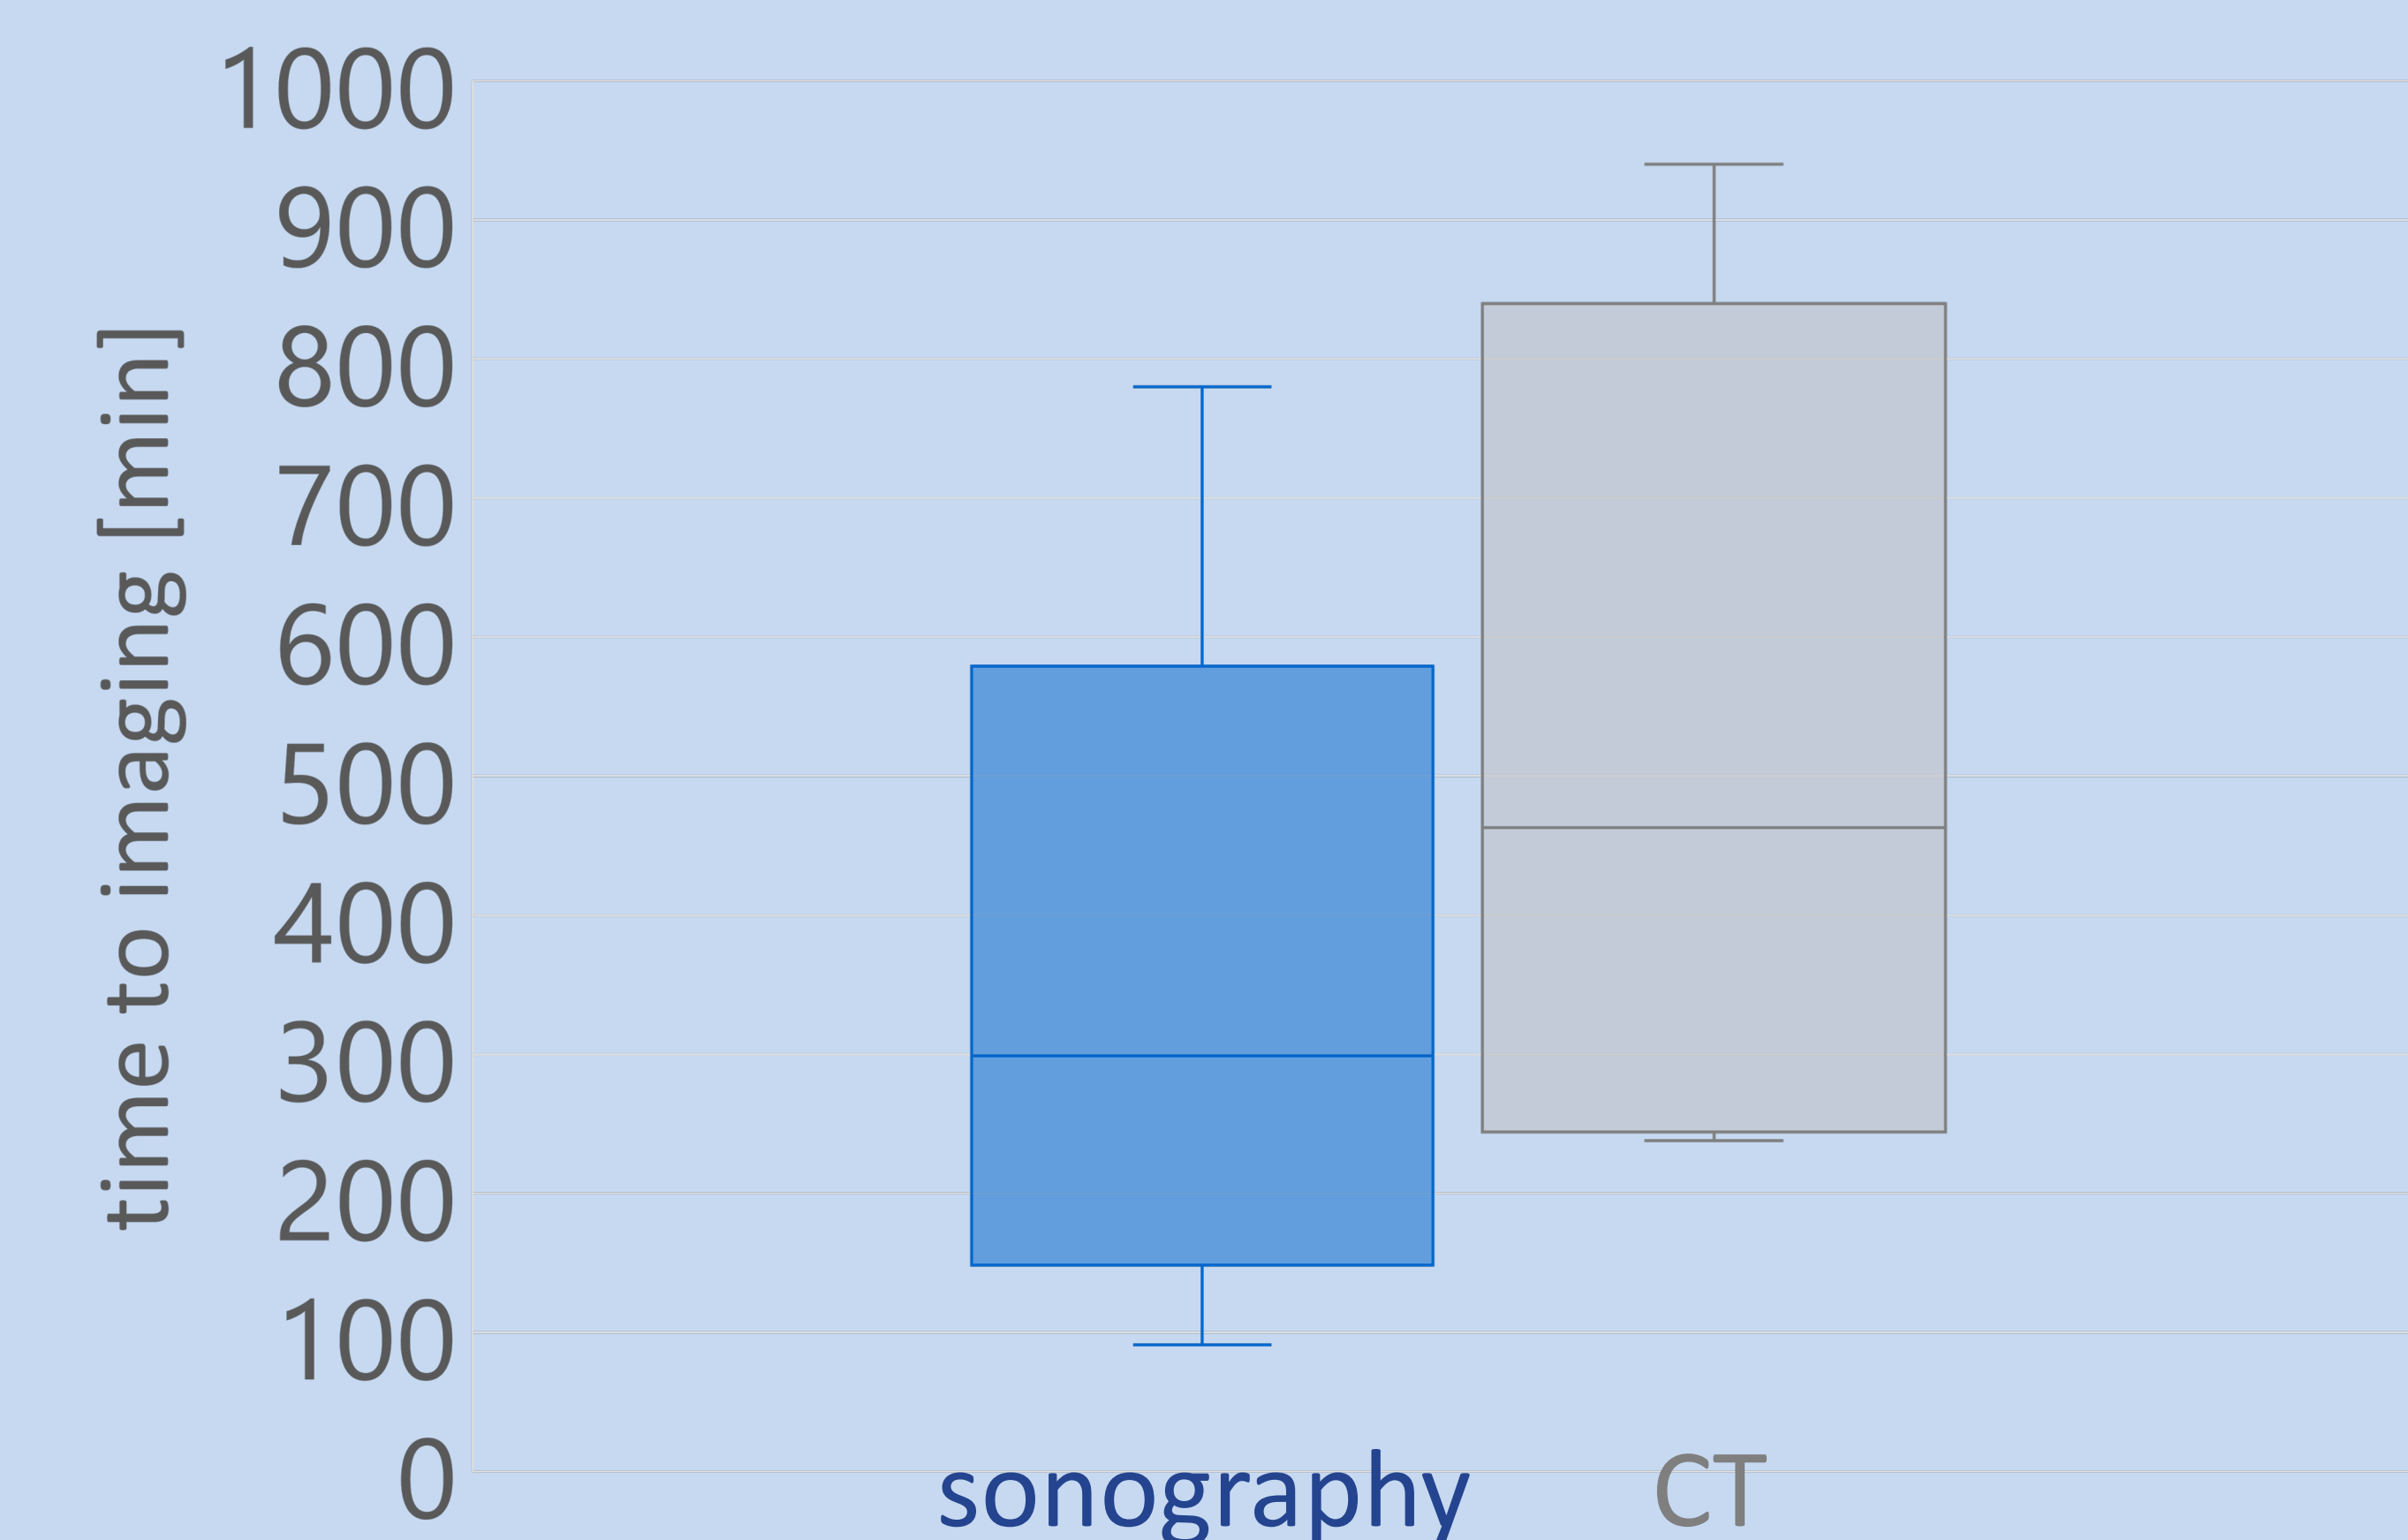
Time to imaging (sonography or CT) at the ED.
